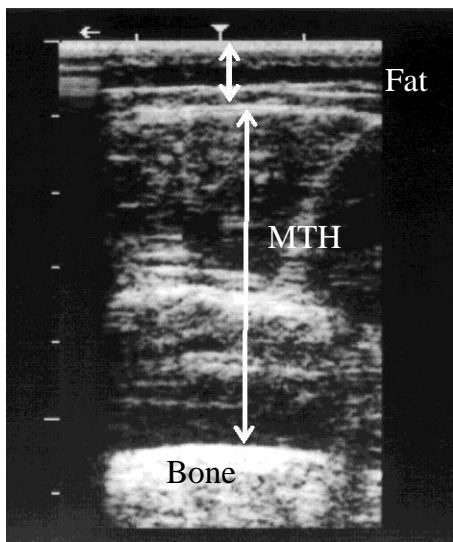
Typical ultrasound image showing transverse scan on the anterior thigh at 50% of thigh length.
